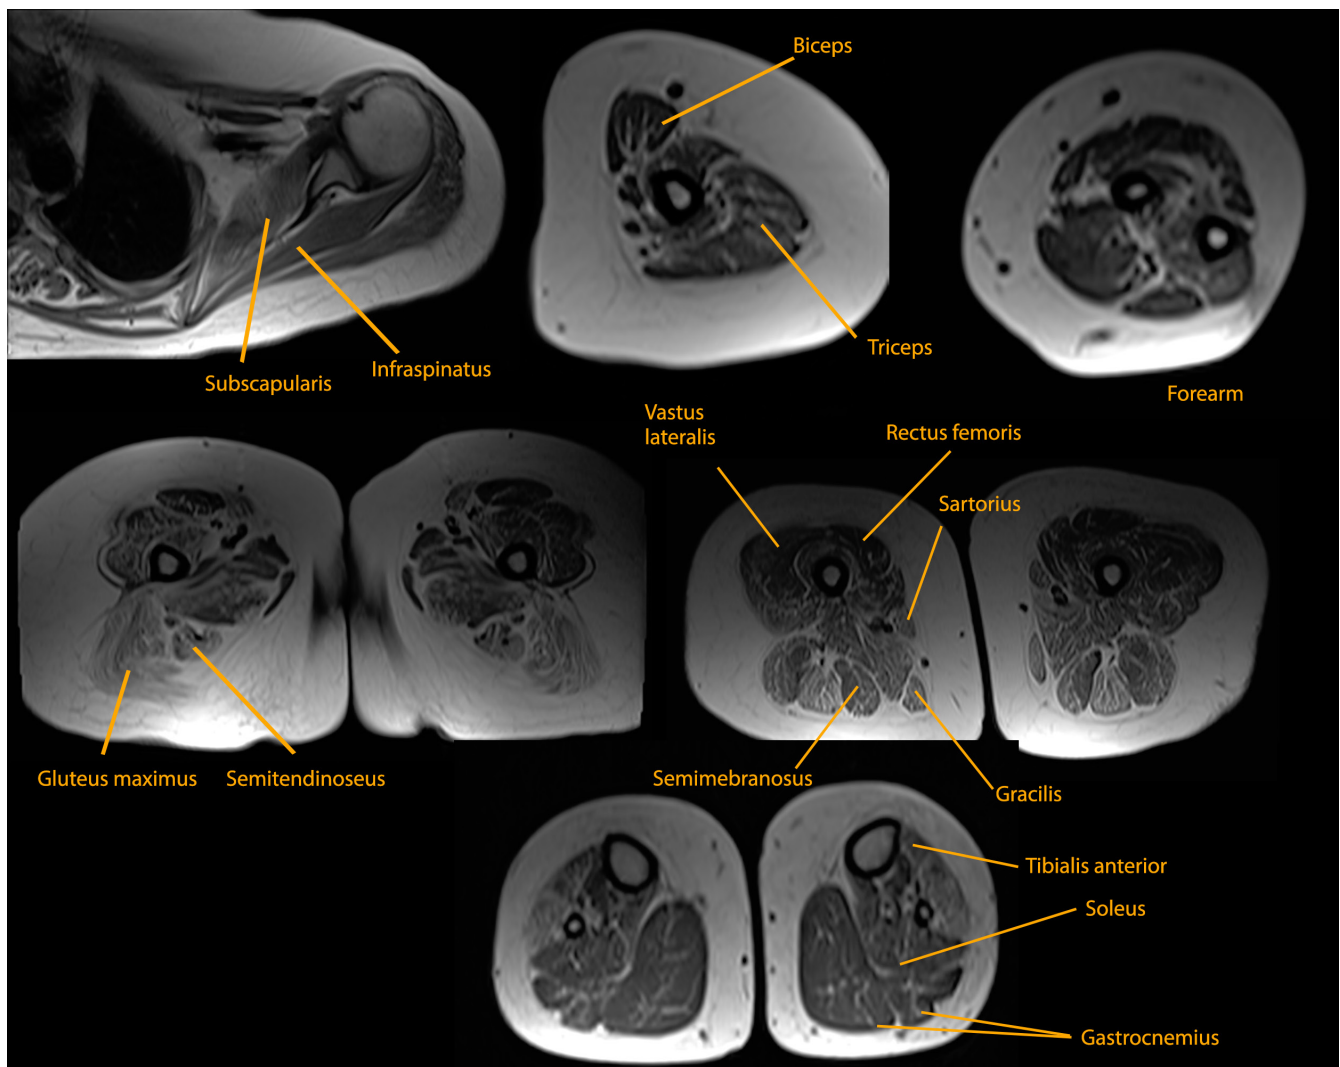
T1-weighted Muscle MRI of the Proband IV-3 in the axial view.
